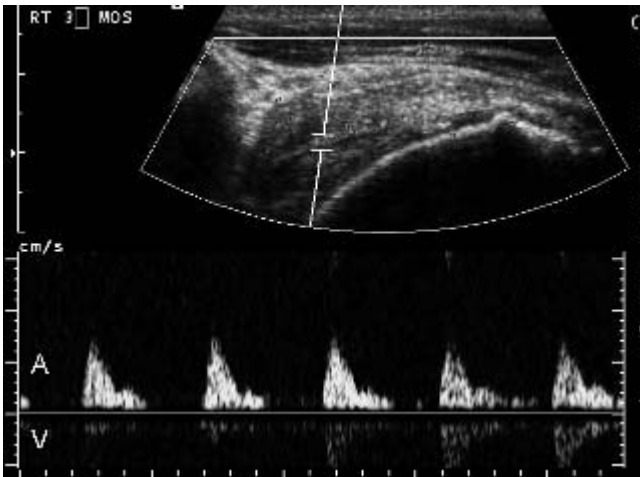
Spectral Doppler tracing differentiating between arterial (A) vasculature and venous (V) flow in the setting of an intact rotator cuff repair at 3 months after surgery.
